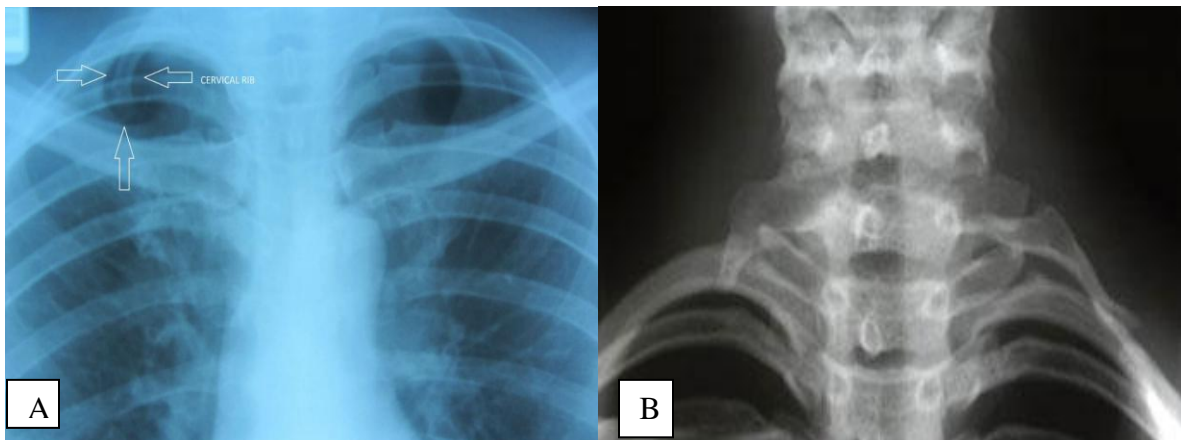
Fig A & B: X-ray showing cervical rib of both cases.
